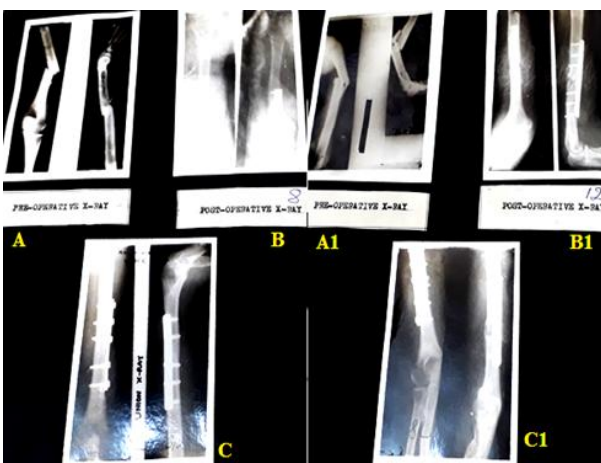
Radiographs: A, A1- pre-operative, B, B1- post-operative, C, C1- union
